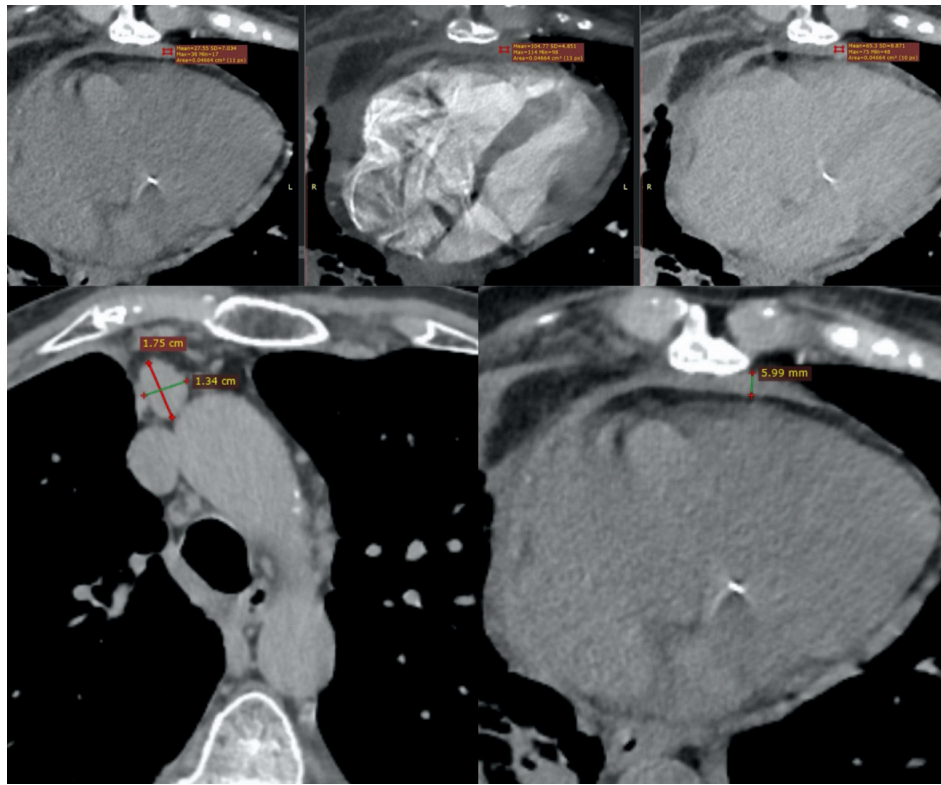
CT findings. Notice the thickened pericardium and lymph node
